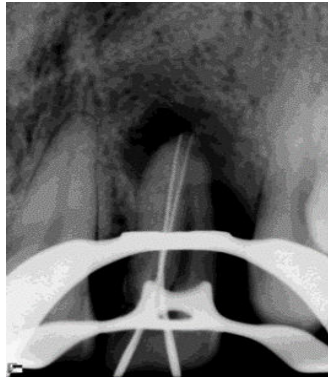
Working length determination on radiograph.
